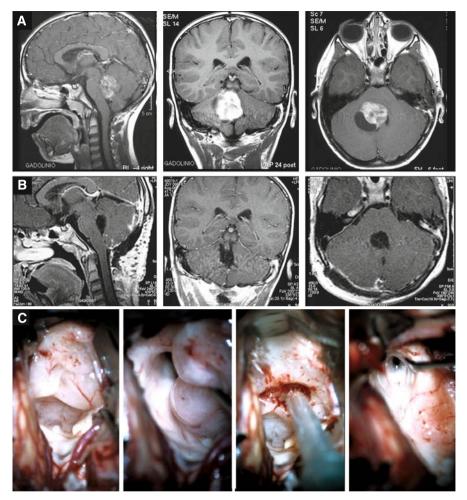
4-year-old child presented with headache, vomiting, ataxia and diplopia. The preoperative contrast enhanced MR images (A) revealed a IV ventricle tumor which was completely removed (B) using a midline suboccipital craniotomy. The tumor resulted as a dorsally exophytic pilocytic astrocytoma originating from the right IVth ventricle floor (C). The complete exeresis was facilitated by the ultrasonic aspirator and at the end the IV ventricle was empty and clean, and the aqueduct opened. The preoperative symptoms reduced over time until finally disappearing completely
